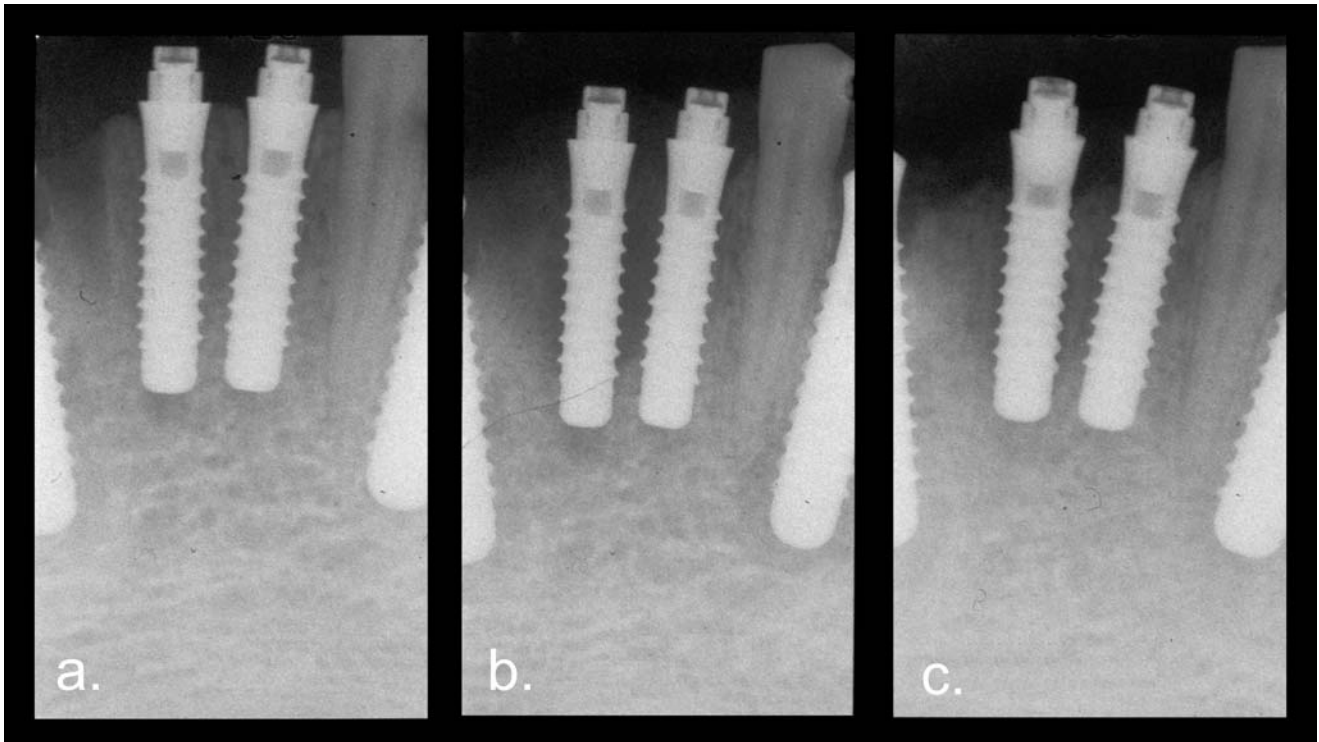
Patient SA, a 20-year-old man with multiple ageneses. (a) Among other implants, two 3.3-mm diameter implants were placed on each side of the symphysis. (b) After 2 weeks, the site became painful and, radiographically, a 10-mm lacuna had appeared. The patient was placed on antibiotics and the symptoms disappeared. (c) After 5 months, the site had remineralized.
